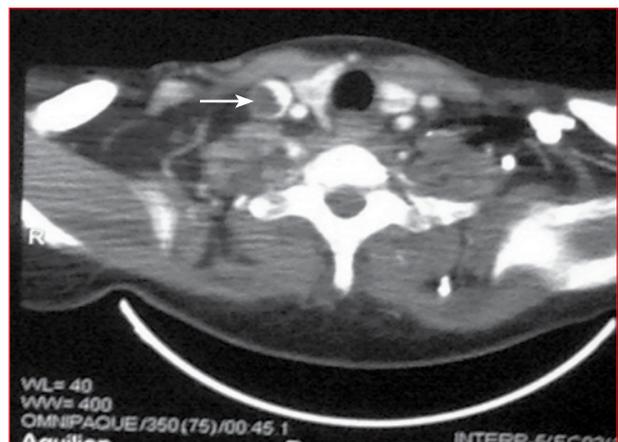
Computed tomography of the chest demonstrating thrombus in the right internal jugular vein (thick arrow) and lytic vertebral lesions (thin arrow)
